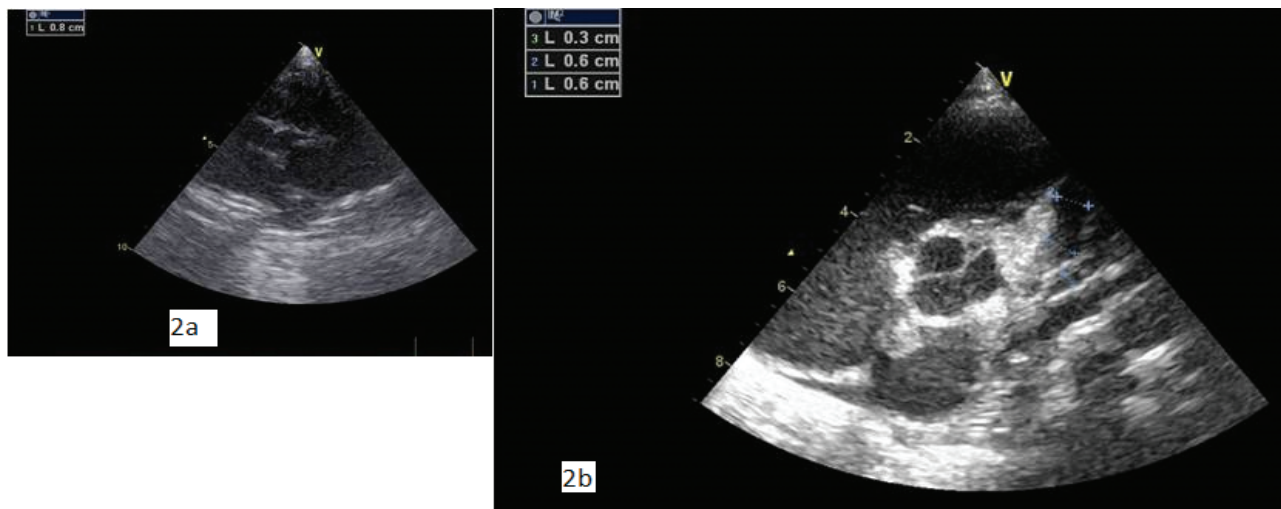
Echocardiogram from the parasternal short-axis view showed important right coronary artery dilation (2 a), left anterior descending artery (LAD) aneurysm, and dilated circumflex coronary artery (2b)
